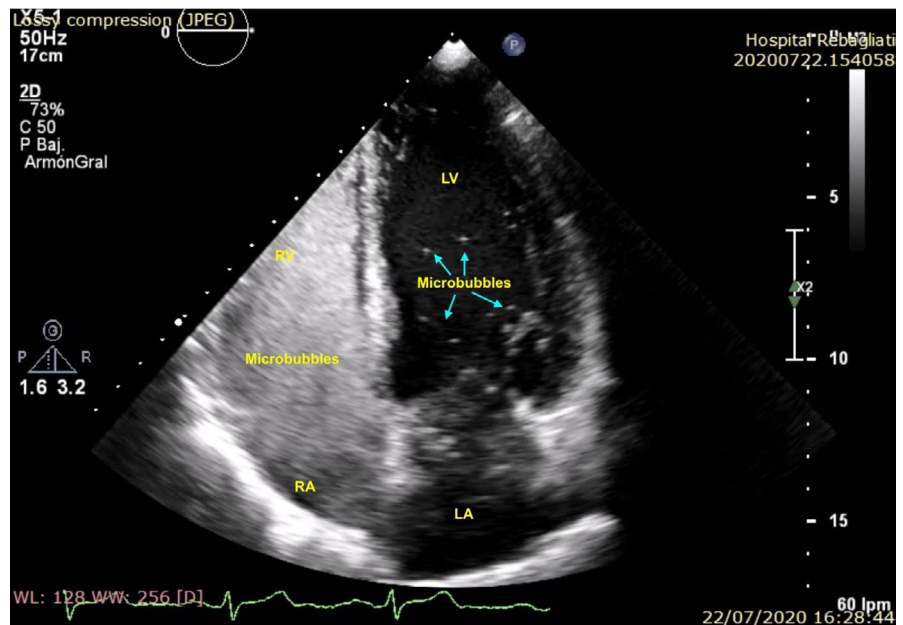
TTE, capture of apical four-chamber view at the third beat showing some bubbles in left side. TTE: transthoracic echocardiography
